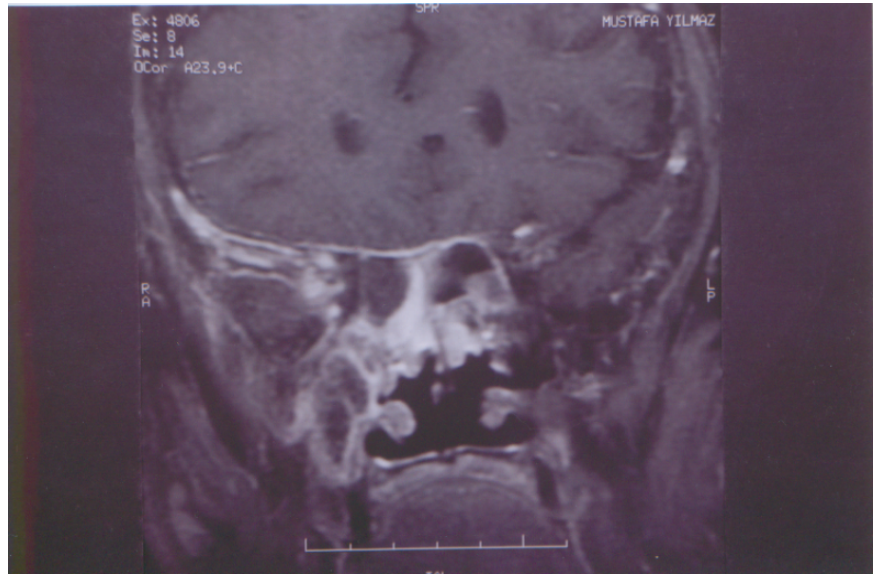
Soft tissue increased of maxillary, sphenoid and ethmoid sinus and contrast-enhancement of dura and extraocular muscles in MRI.
